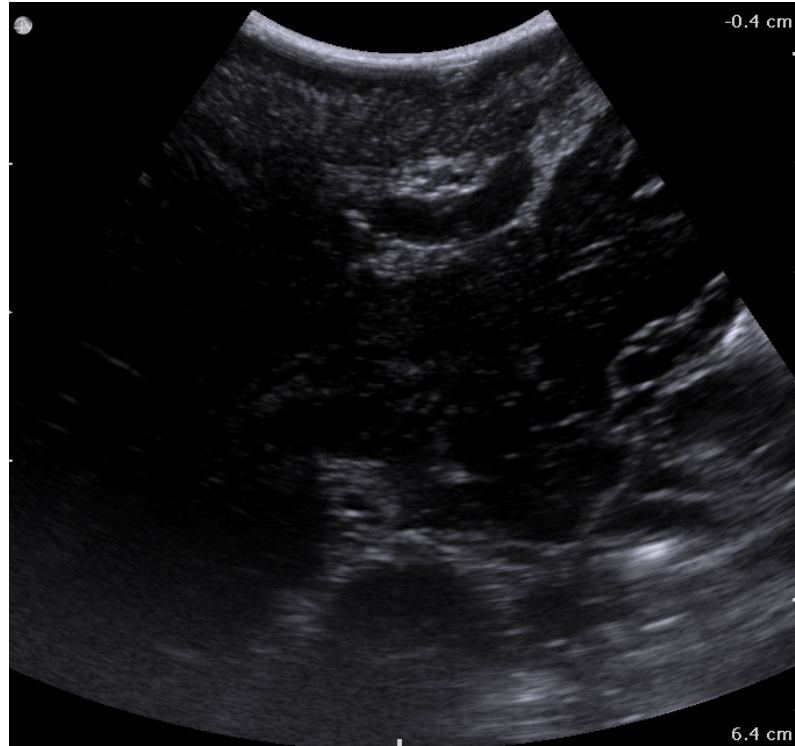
B-mode ultrasound acquisition
